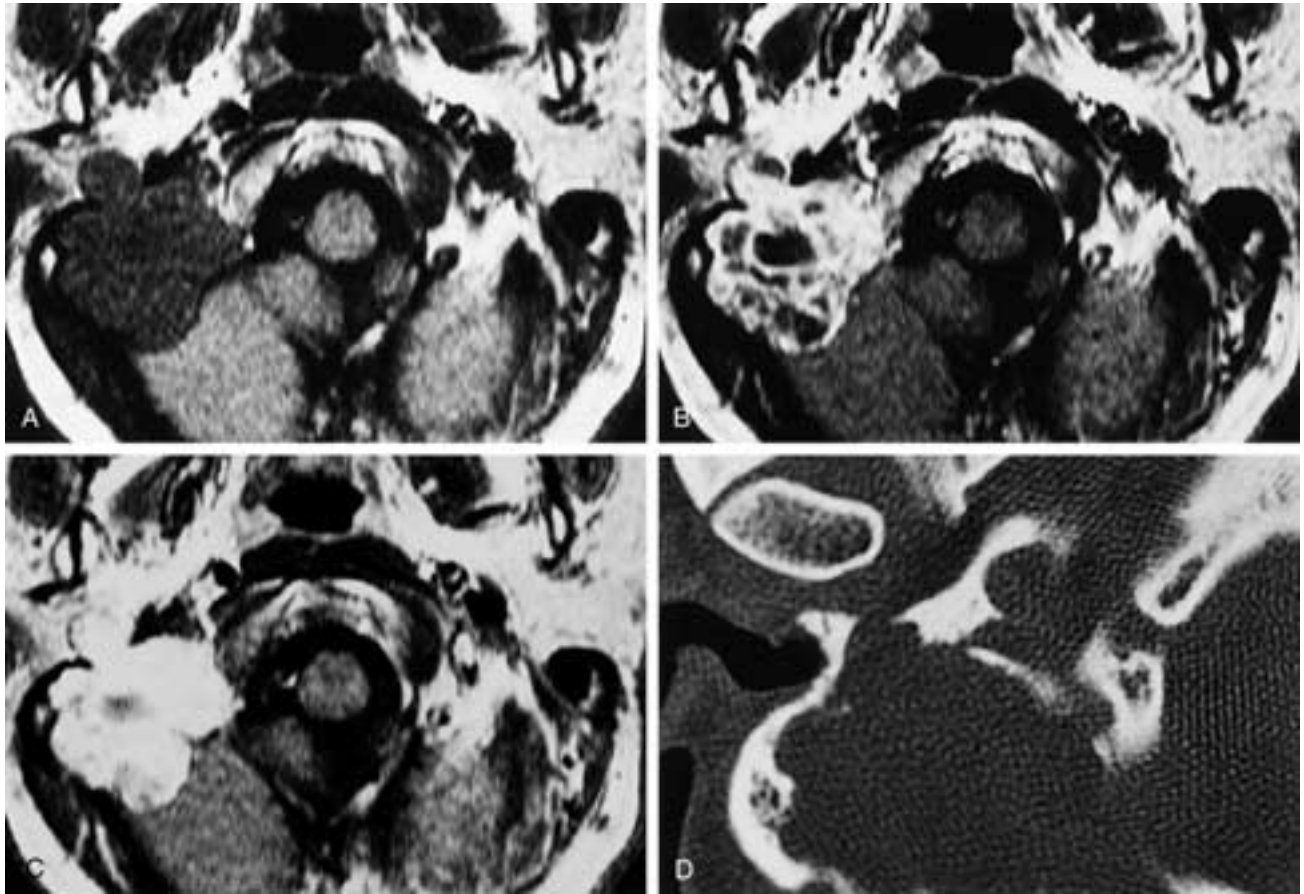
Large cystic mastoid segment facial schwannoma. A, T1-weighted image. B, Gadolinium T1-weighted image. C, Gadolinium T1-weighted image delayed 20 minutes. The images show a multilobulated, multicystic tumor protruding beyond the right mastoid cortex anteriorly, posteriorly, and medially. The cystic appearance is common in large schwannomas. D, Axial CT shows sharply and smoothly defined bone margins reflecting the slow growth rate of the tumor. (Compare with Figs. 25-115 and 25-118.)
